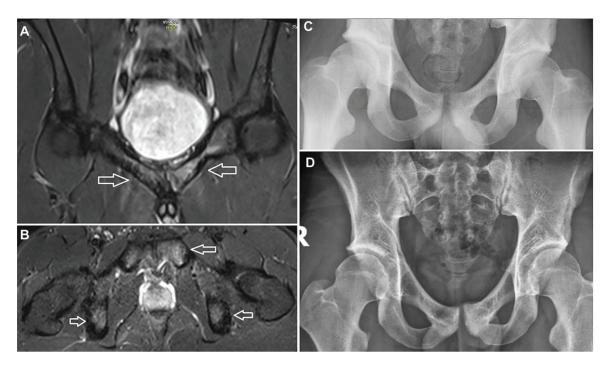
Images from a 19-year-old patient with osteitis puble. (A,B) Preoperative MRI scan demonstrated diffuse bone marrow edema in public symphysis and surrounding public arms, combined with disruption of the public symphysis joint. (C) Postoperative first day radiograph of the patient. (D) Pelvis radiograph of the patient at 63 months postoperatively showed no significant degeneration or instability. MRI, magnetic resonance imaging.
